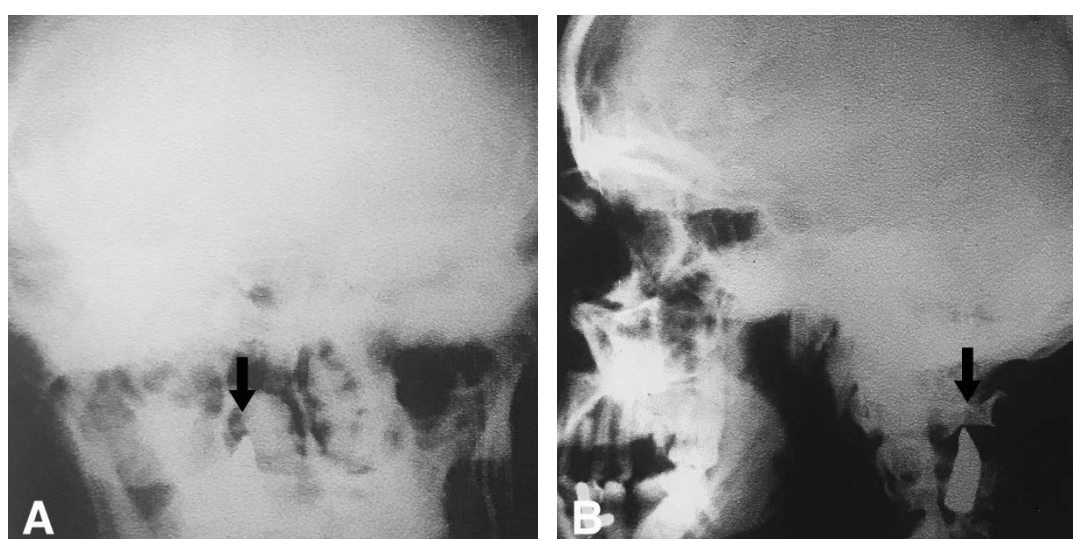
Plain radiography performed after the spinal cord related symptoms have occurred. The bullet had migrated to the spinal canal extending from the lower edge of C1 to the C3 vertebral body: A) Anterior view; B) Lateral view.
